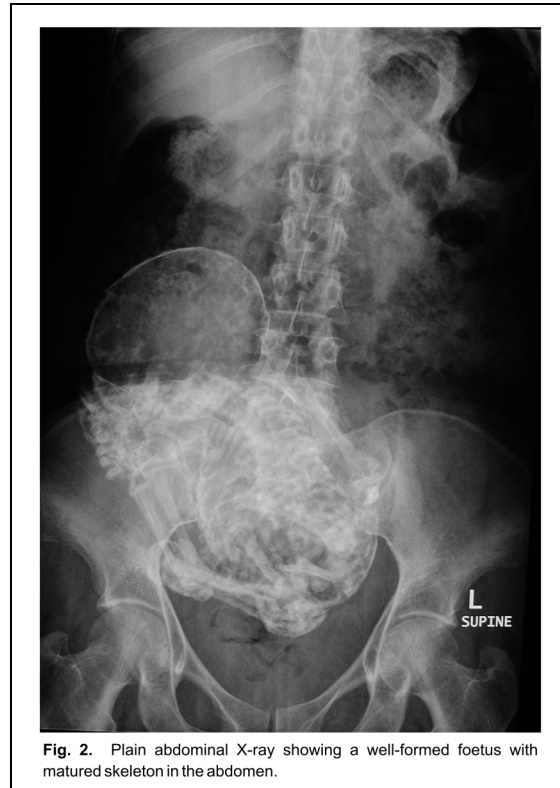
Plain abdominal X-ray showing a well-formed foetus with matured skeleton in the abdomen.
